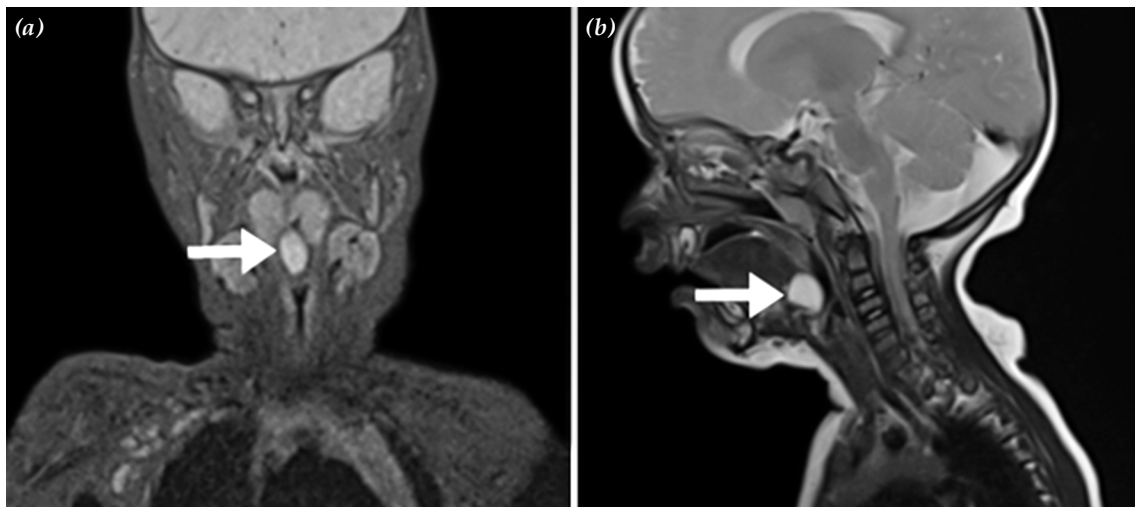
Imaging of midline vallecular cysts (arrows) in Patient 1. (a) Coronal T₂-weighted magnetic resonance imaging. (b) Sagittal T₂-weighted magnetic resonance imaging showing a 13×12-mm hyperdense cyst mass at the base of the tongue.
